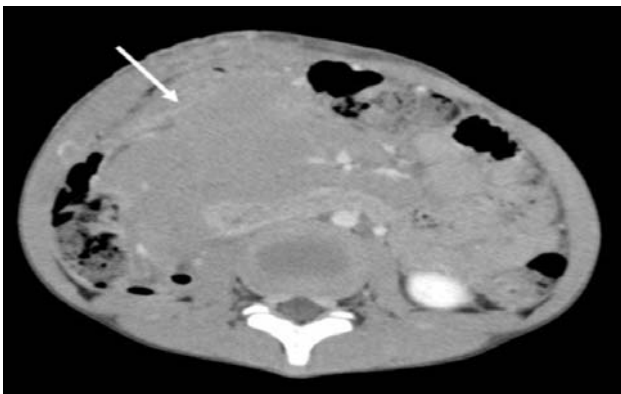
Axial C/E CT scan: large soft tissue density mass centered on right hemi abdomen, involving head of pancreas and duodenal head (case of Burkitt lymphoma)
